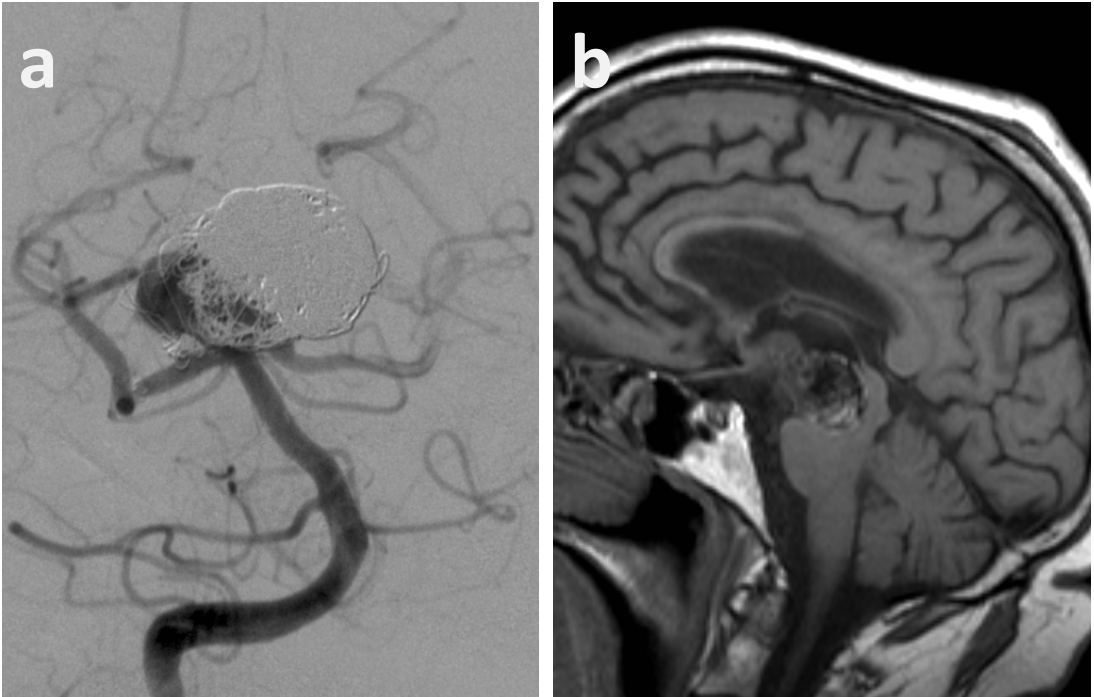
A marked recanalization is observed in a DSA image (a) obtained 30 months after stent-assisted re-embolization of a giant basilar tip aneurysm. In spite of five successive endovascular treatment attempts, permanent occlusion of the recurrent aneurysm was not achieved and the patient developed brain stem compression symptoms as seen in a T1-weighted MRI image (b); the patient died within one month.
